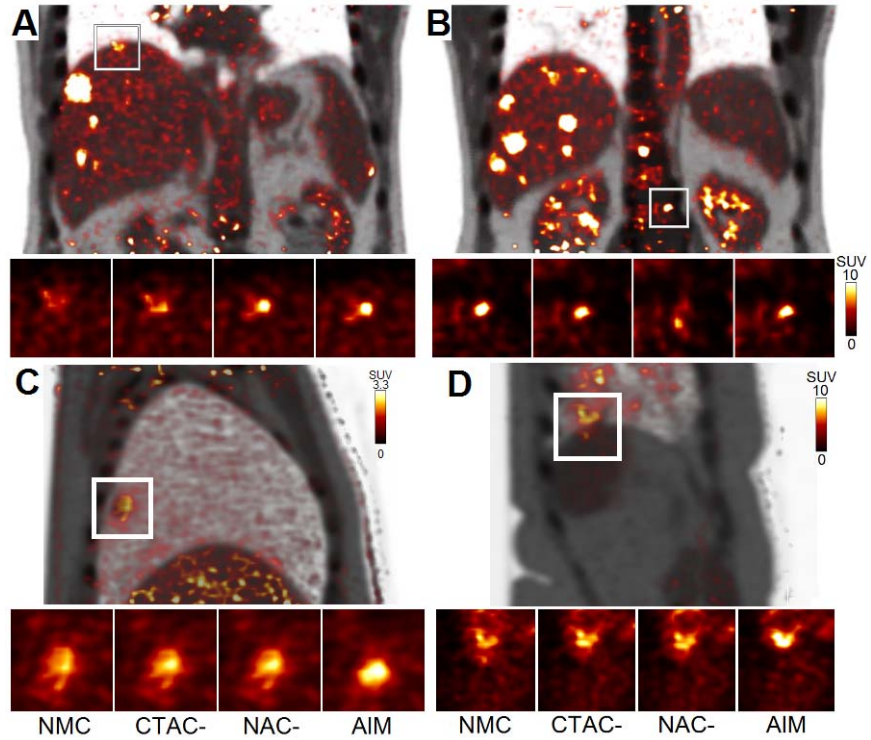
Sample slices of final motion-corrected reconstructions of ^{18}F -FDG studies. A and B show coronal slices from Study #2. C shows Study #3, and D shows Study #9. PET and CT fused images are shown for the whole FOV. Zoomed-in images of local ROIs show results for no motion correction (NMC) and different correction methods.
